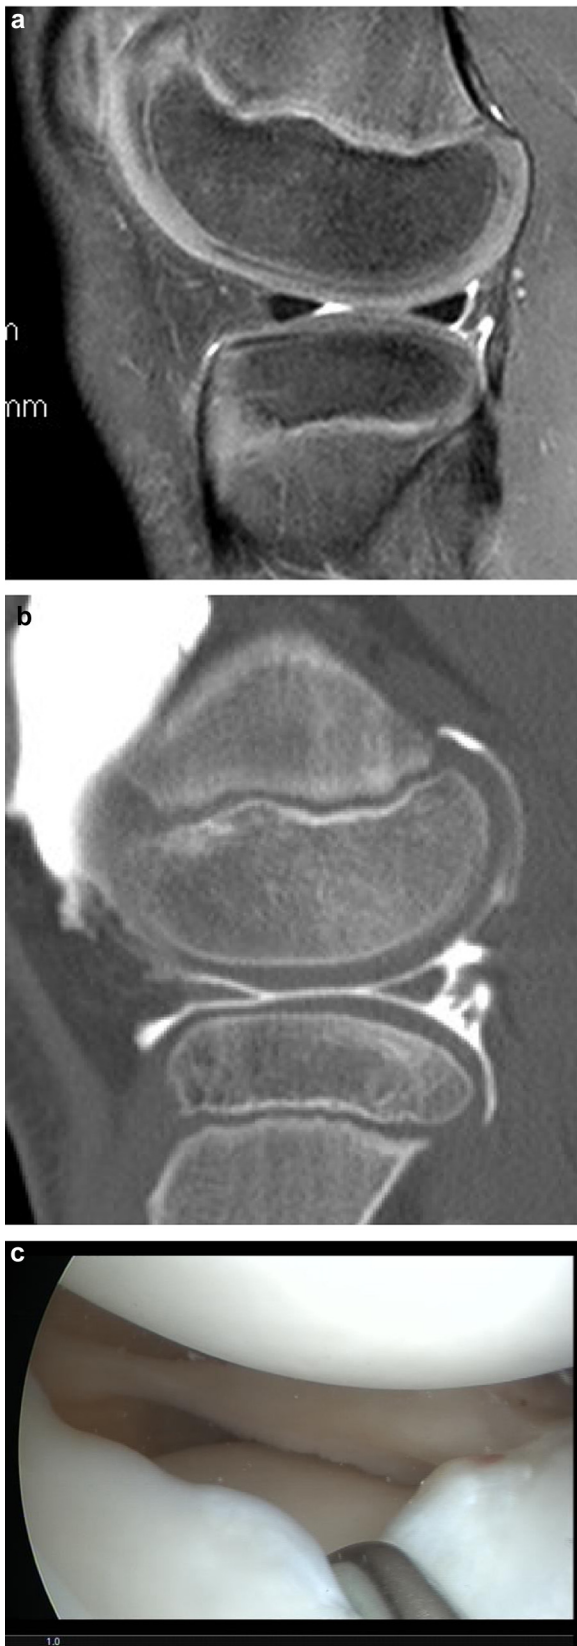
Hypermobile meniscus: a: MRI; b: CT-arthrography; c: arthroscopy.
